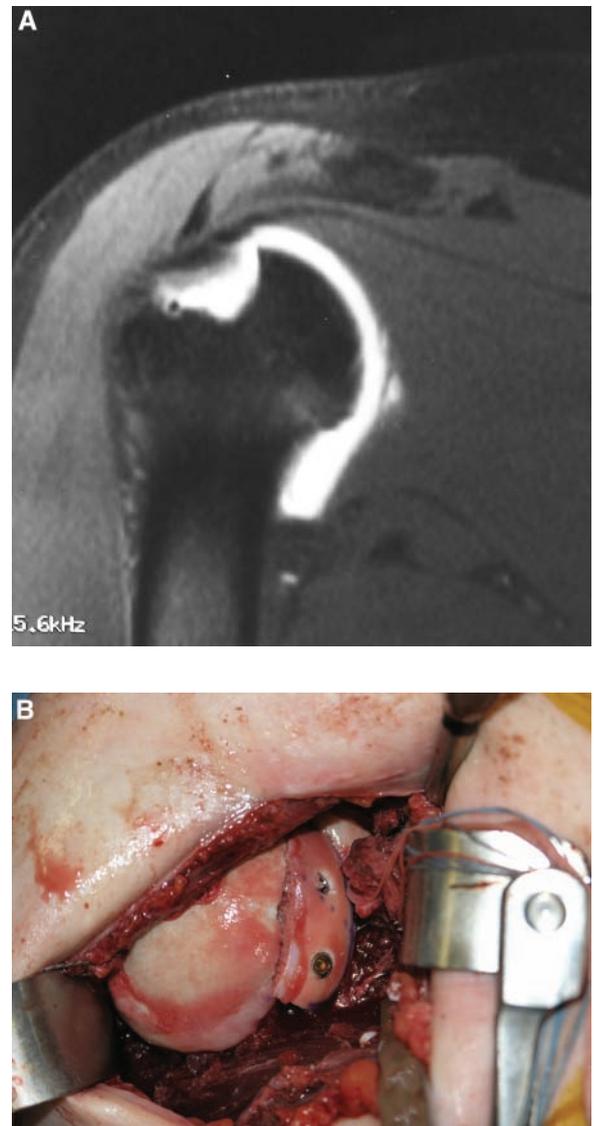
A, coronal MRI demonstrating large Hill-Sachs lesion in a patient with recurrent instability. There is approximately 30% involvement of the humeral head. B, intraoperative view of allograft affixed at the site of chondral injury with 2 countersunk screws.
